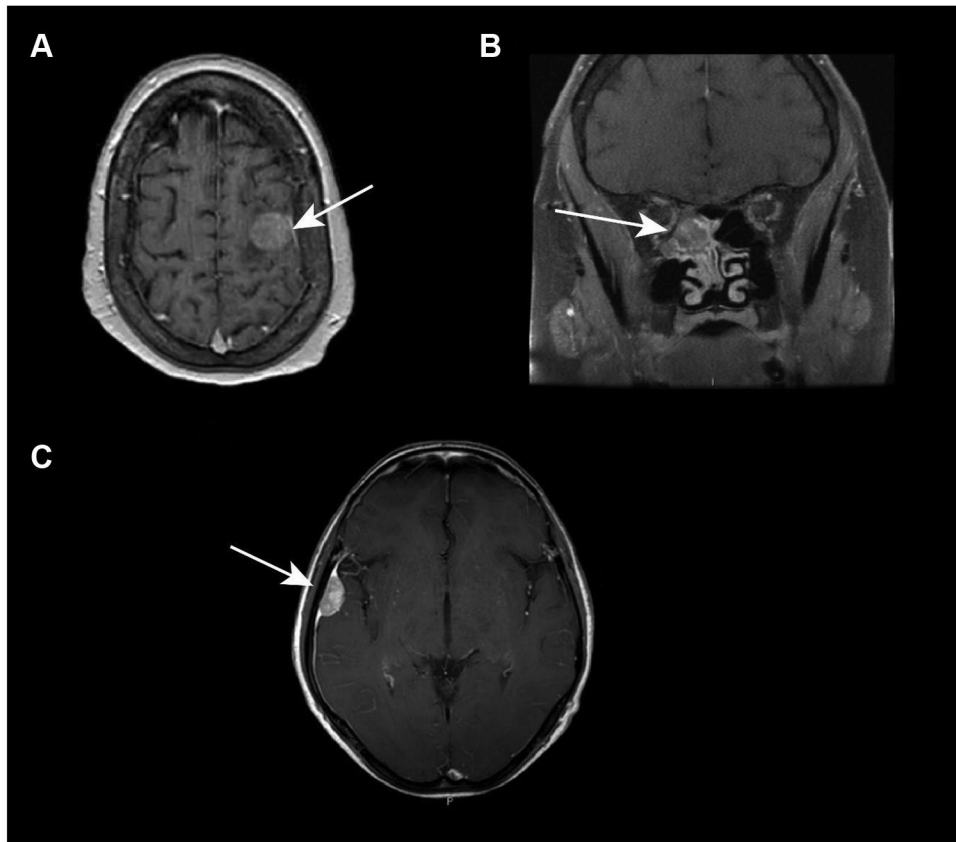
MRI results of cases 1, 2, and 3. (A) T₁-weighted MRI of the brain of case 1 revealing meningioma overlying the left frontoparietal convexity (white arrow). (B) T₁-weighted MRI of the brain of case 2 revealing meningioma extending intra-cranially and laterally into the cavernous sinus (white arrow). (C) T₁-weighted MRI of the brain of case 3 revealing meningioma adjacent to the right sylvian fissure (white arrow). MRI, magnetic resonance imaging.
